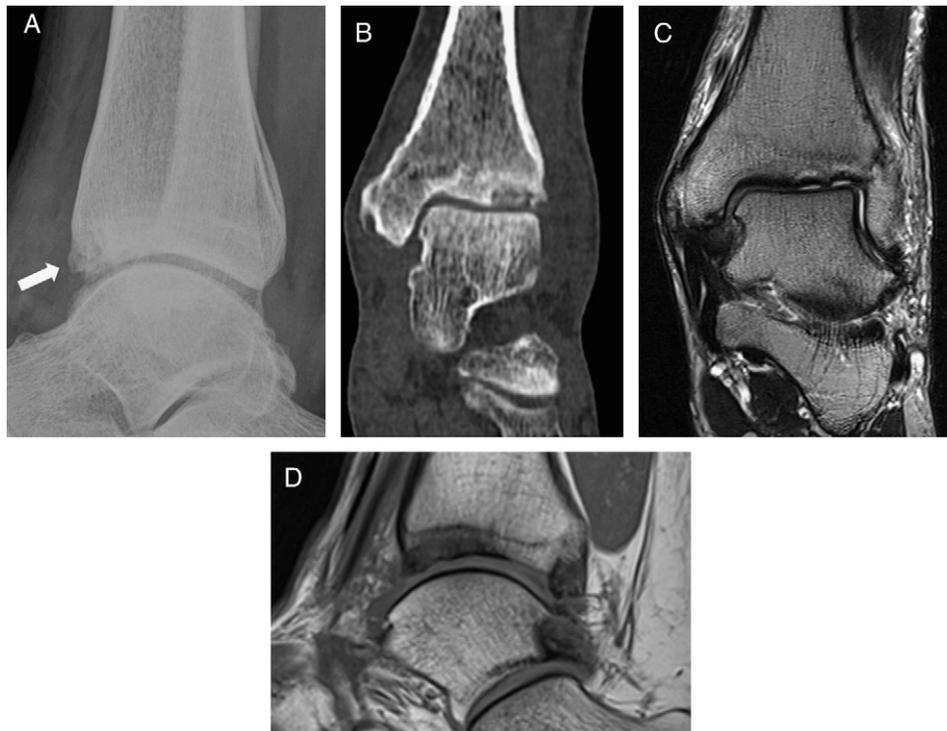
Preoperative management. The lateral radiograph of the ankle shows increased translucency of the anterior distal tibia (arrow) (A). Computed tomography scan shows the defect located anterolateral on the distal tibia totaling 1520 mm³ (B). Magnetic resonance image shows edema of the subchondral bone and thinning of cartilage above the osseous defect in coronary (T2 turbo-spin-echo [tse]) (C) and sagittal (T1 tse) planes (D).
